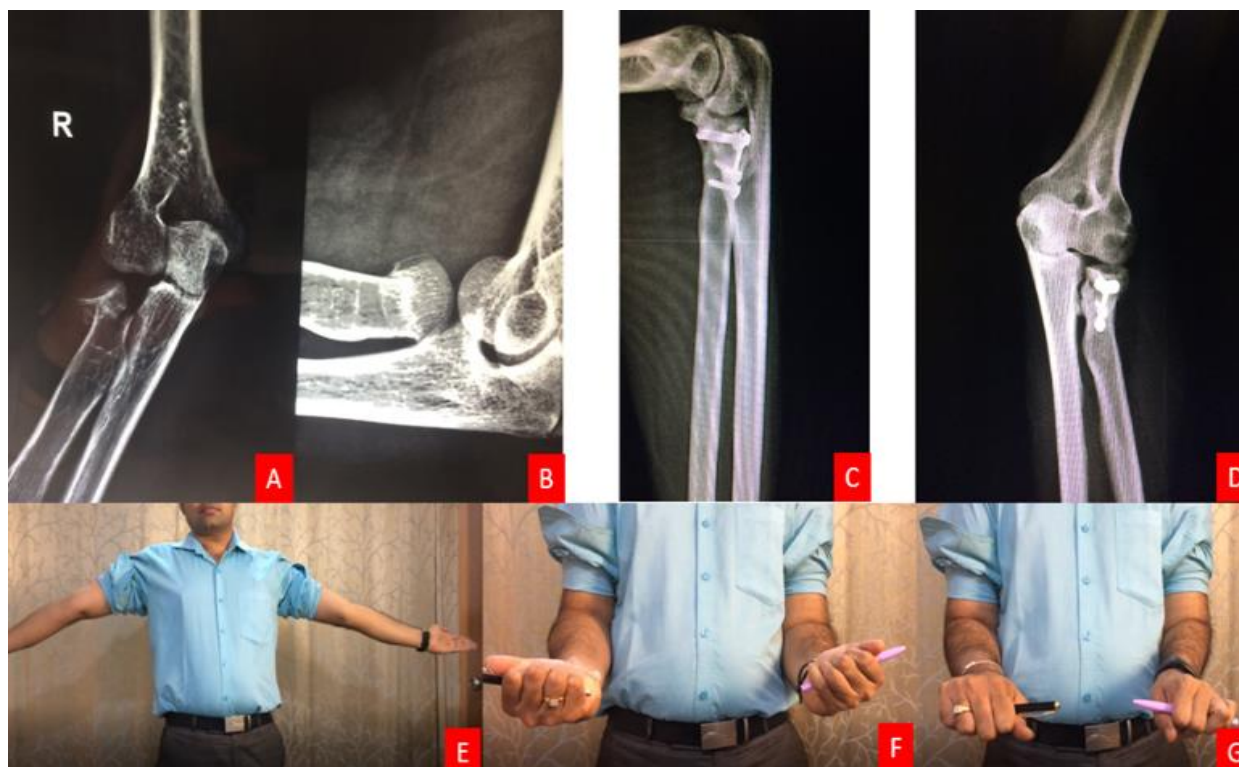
A & B) Pre-operative x-ray showing a Mason’s type II radial head fracture. C & D) Follow-up X-ray showing union with no features s/o heterotrophic ossification or radio-capitellar arthritis. E, F & G) Patient assessment at follow-up demonstrating calculation of ROM by physiotherapist.
